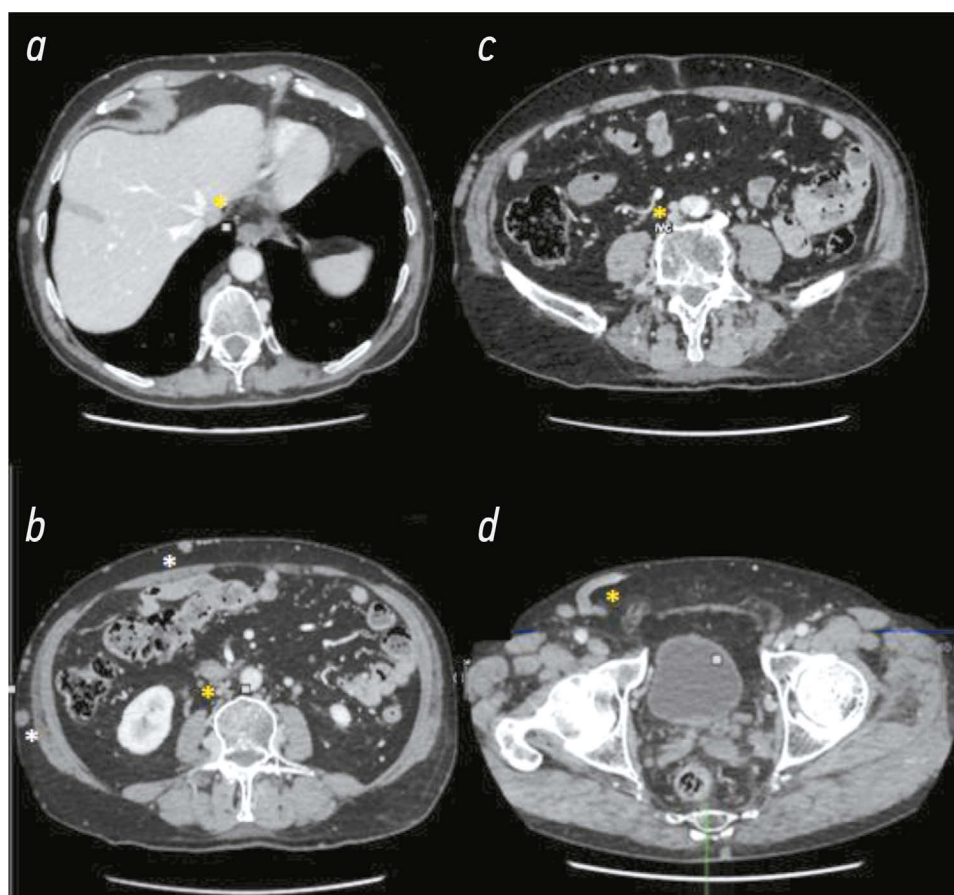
Computed tomography images of the axial section of the abdomen (portal phase): *a*) The small suprarenal IVC is indicated by a yellow asterisk. *b*) Lower in the abdomen, the yellow asterisk indicates the hypoplastic IVC, and the hypertrophic collateral venous circles in the anterior abdomen wall on the right are indicated by a white asterisk. *c*) Another lower axial section showing the small IVC (yellow asterisk). *d*) The drainage on the right side is accomplished by a constant iliac vessel (yellow asterisk).
